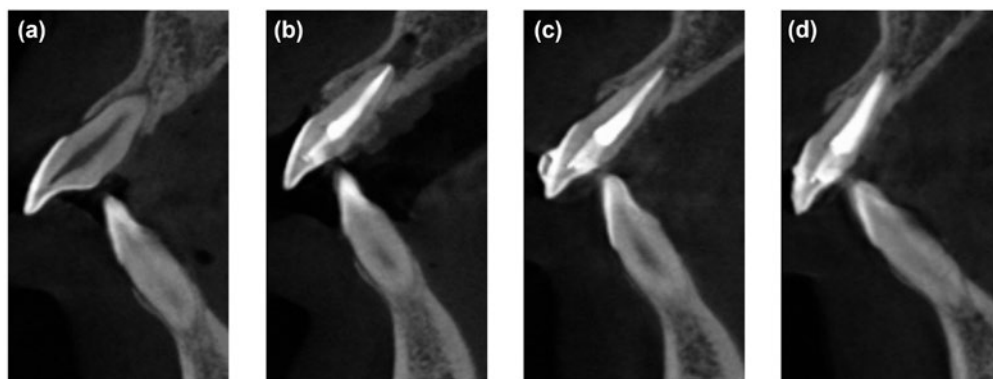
CBCT images before and after dental implant system-assisted IR. Preoperative imaging data (a). Immediate postoperative imaging data (b). Imaging data 6 months after dental implant system-assisted IR (c). Imaging data 1 year after dental implant system-assisted IR (d).
